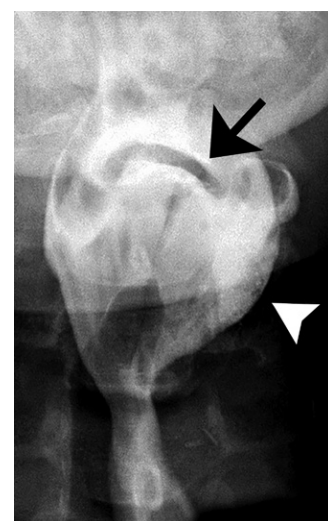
Hypotony of the left pharyngeal wall in a 59-year-old woman. Frontal radiograph of the pharynx during swallowing shows bulging of the left pharyngeal wall (arrowhead) and an asymmetric tilt of the epiglottis (arrow). Findings were due to a nerve injury during surgery for resection of a tumor in the base of the skull.
